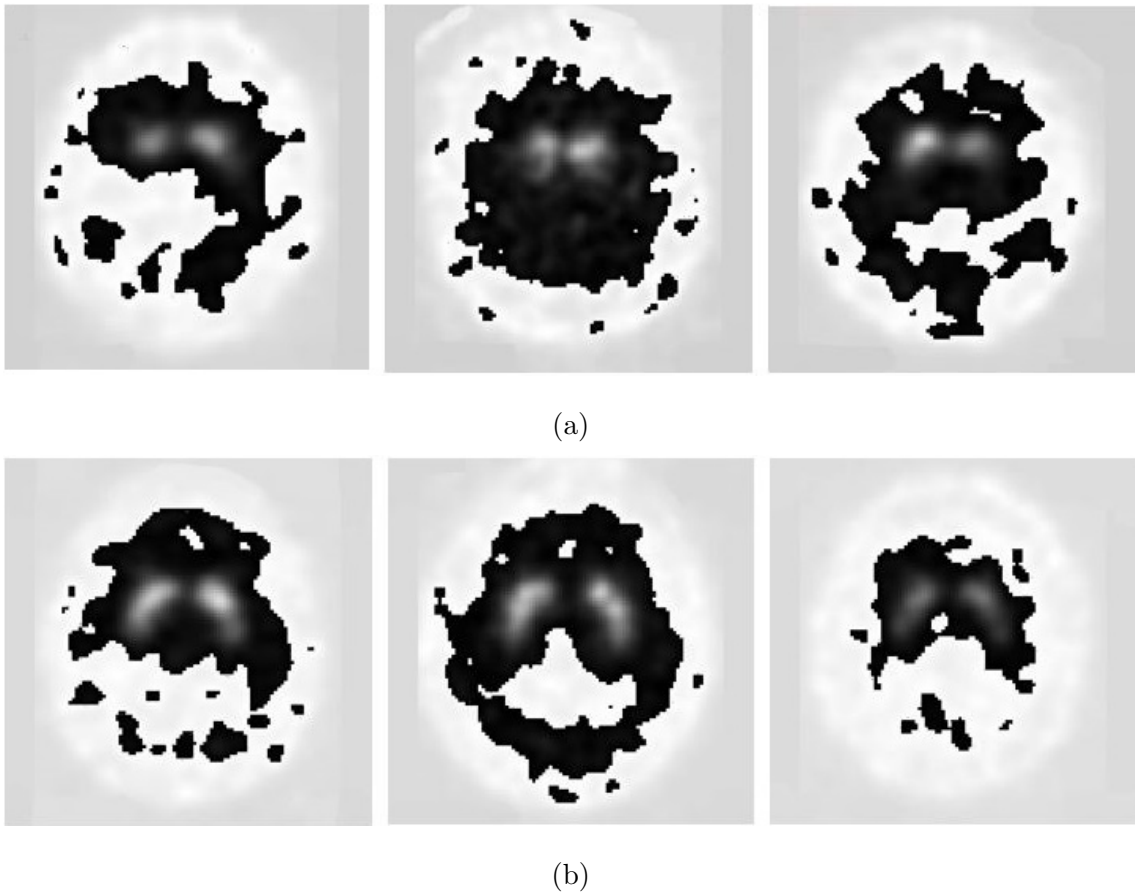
SPECT scans showing examples of (a) Normalized PD patient and (b) Normalized healthy control
